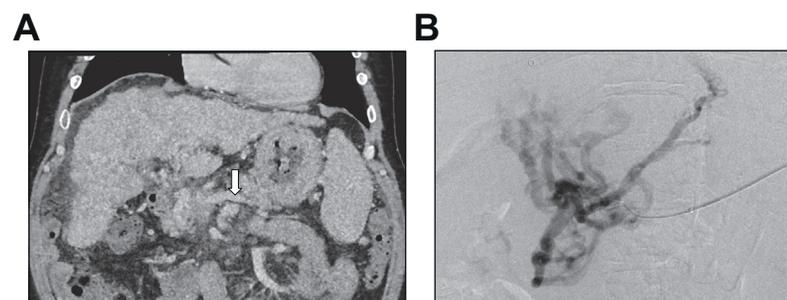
Patient with cavernomatous transformation. (A) Coronal contrast-enhanced CT demonstrates cirrhotic liver, cavernomatous transformation and patent splenic vein (arrow), (B) trans-splenic splenoportography confirms absent main portal vein with cavernomas.
